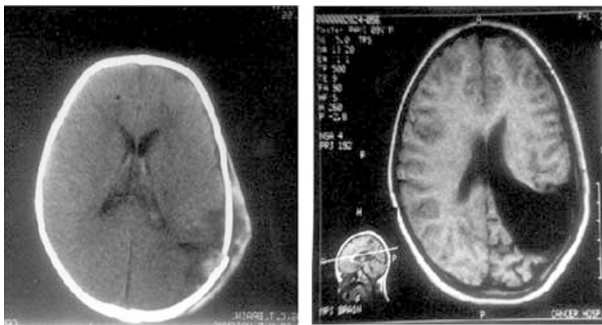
(left): CT scan of the patient taken at the time of head trauma in 1993 revealed a left parieto-temporal bone fracture with oedema of the underlying tissue. A subcutaneous haematoma overlying the fracture was present. (right): MRI scan of the brain demonstrating a large porencephalic cyst starting from the left lateral ventricle to the fracture site. There is no evidence of an actual bulge of the cystic mass outside the fracture site or a midline shift of the ventricle intracranially demonstrating normal ICP at present.
